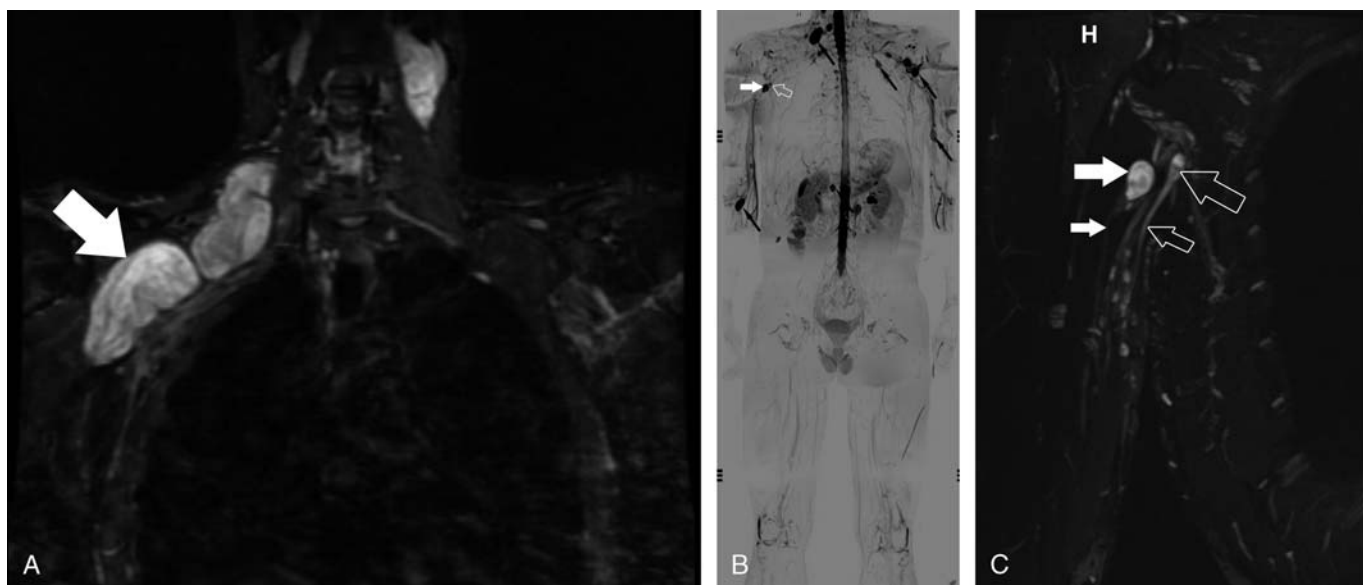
A 42-year-old man with neurofibromatosis II. A, Coronal fat-suppressed T2-weighted MR image shows an extensive neurofibroma (arrow) of the right brachial plexus. After initial tumor resection, the patient complained loss of elbow flexion. EMG/NCS showed partial lateral fascicle injury. The Oberlin's transfer was performed to treat musculocutaneous nerve deficit. B, Postoperative follow-up MR image of the whole body 4 years later identifies multiple neurofibromas (some of which are exemplarily marked by small black arrows) as well as two recurrent neurofibromas in the lateral plexus (open and white arrow) of the operated right side. C, Dedicated brachial plexus MR neurography after 6 years provides detailed view, showing that the neurofibromas arise from the musculocutaneous (white arrows) and ulnar nerve (open arrows). Despite the recurrent neurofibromas the patient had an excellent outcome with biceps strength M5 and a DASH score of 1. H, humeral head.
